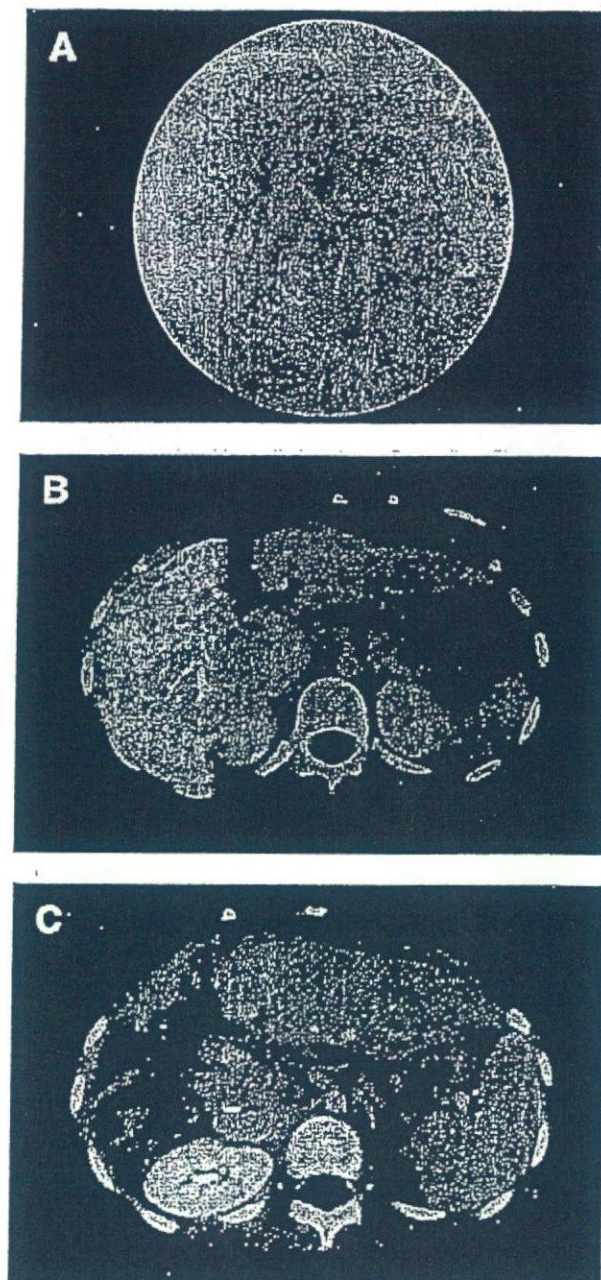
(A) Portal phase of angiography shows cavernous transformation of the native right portal vein after portal vein diversion. (B) After PTPE for native right portal vein. Right portal vein was occluded by Lipiodol. (C) CT after native right hepatectomy. The volumetric analysis showed 416 mL in the graft and 106 mL in the native caudate lobe.
